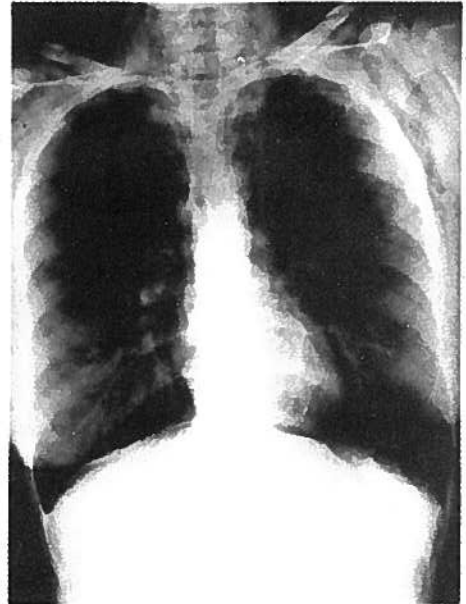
Chest roentgenogram showing pneumo-mediastinum following severe paroxysm from bronchial asthma. The extravasated air was absorbed spontaneously.
